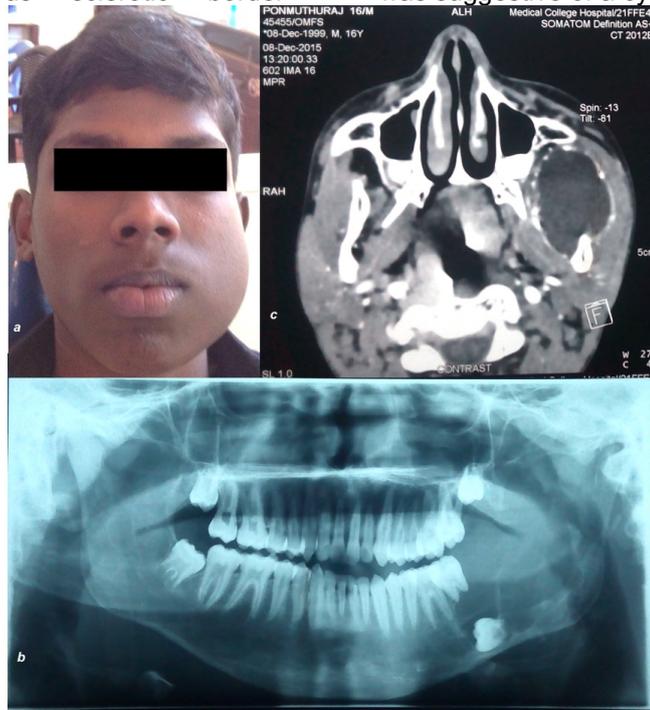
The extra oral photograph (a) showing a unilateral swelling on the left side of the face, Orthopantomograph (b) showing a multilocular radiolucency and computed tomography (c) showing well defined unilocular expansile lytic lesion involving the body, ramus and condylar process of mandible.
